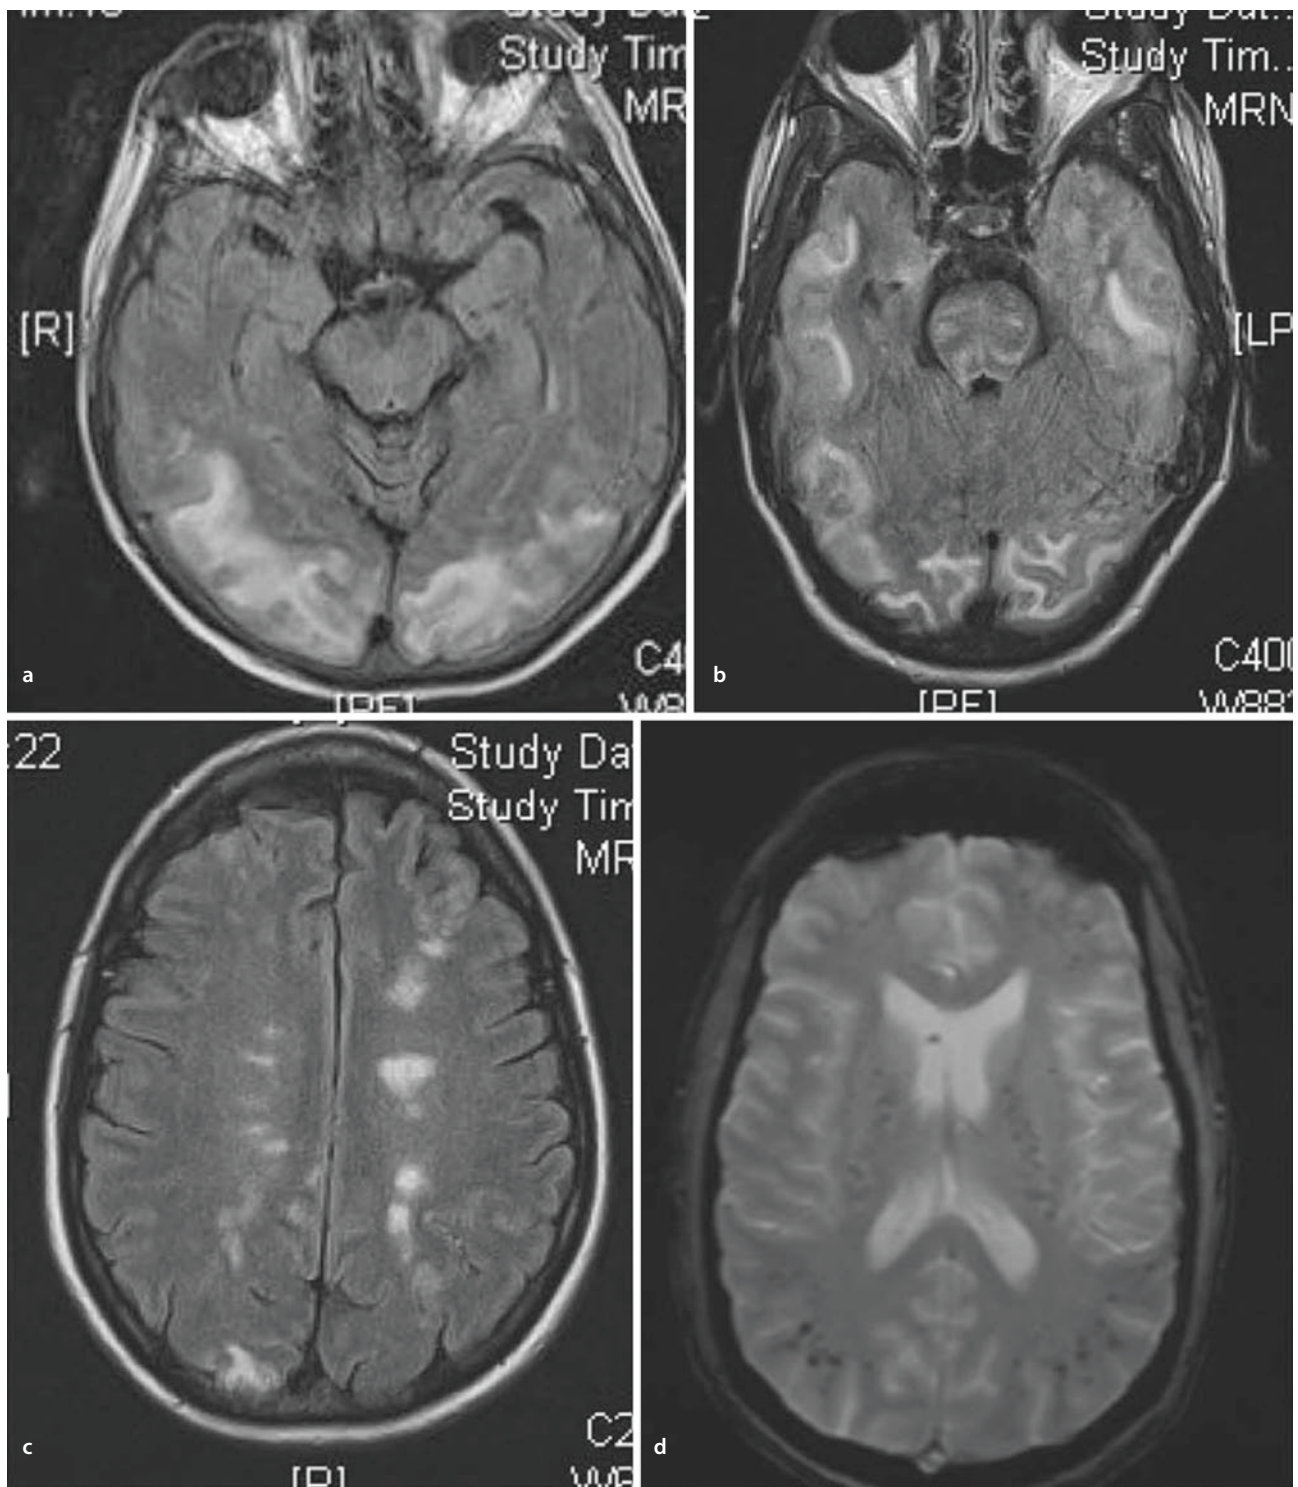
Posterior reversible encephalopathy syndrome (PRES) variants. a Classic PRES with bilateral posterior signal abnormality on FLAIR MRI. b Bilateral predominantly, but not exclusively posterior signal abnormality on FLAIR MRI reflects vasogenic edema. c Multiple areas of FLAIR abnormality in periventricular region on FLAIR MRI in patients with thrombocytopenia on tacrolimus after HCT for AML. d Same patient as in b with gradient echo MRI (c) showing evidence of small hemorrhages in affected areas. *FLAIR* indicates fluid-attenuated inversion recovery, *MRI* magnetic resonance imaging, *HCT* hematopoietic cell transplantation, *AML* acute myeloid leukemia. Pruitt et al. (2013)
